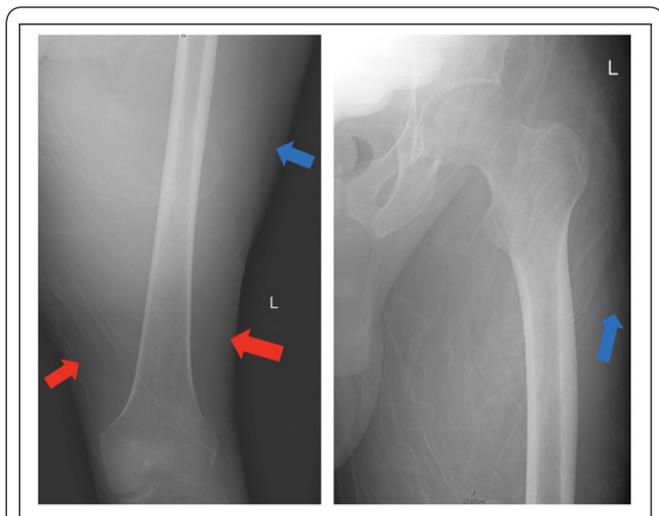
AP radiographs of the left lower extremity show a thin layer of fat (blue arrows) superficial to the muscle tissue. There is some edema interposed within the subcutaneous fat evident by some strand-like hyperdensity in the fat (red arrows). Normal areas of fat have a hypodense, dark appearance. The femur maintains a normal structure and morphology. There is a moderate amount of muscular tissue. Some loose cloth material overlies the mid and proximal femur.
